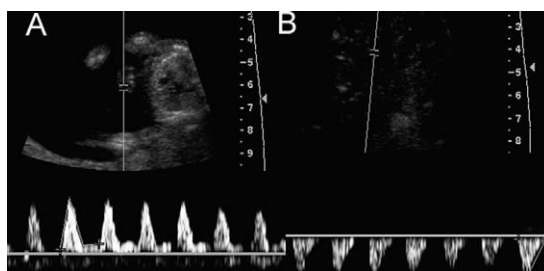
Pulse-wave Doppler in a TTTS case with abnormal umbilical artery flow. (A) Normal umbilical artery Doppler flow in twin A. (B) Absent end diastolic flow in the umbilical artery of twin B.
